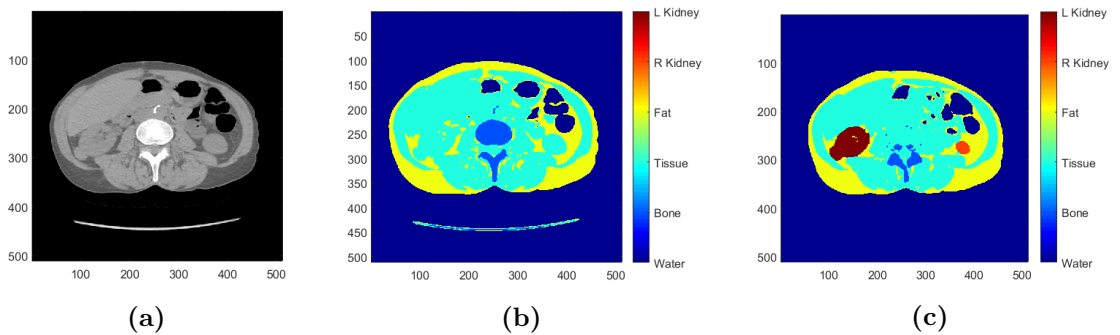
The CT scan segmentation process (a) input CT scan slice, (b) result of automatic segmentation of non-fatty tissue, fat and bone. The kidneys are defined as non-fatty tissue in this step, (c) result of manual segmentation of right and left kidneys. The intermediate step of removing the table below the patient has not been shown.
